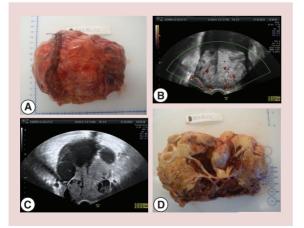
Endometrioid adenocarcinoma with mucinous areas. (A) External surface; (B) color Doppler; (C) B-mode, and (D) internal macroscopy of a endometrioid adenocarcinoma with mucinous areas.
